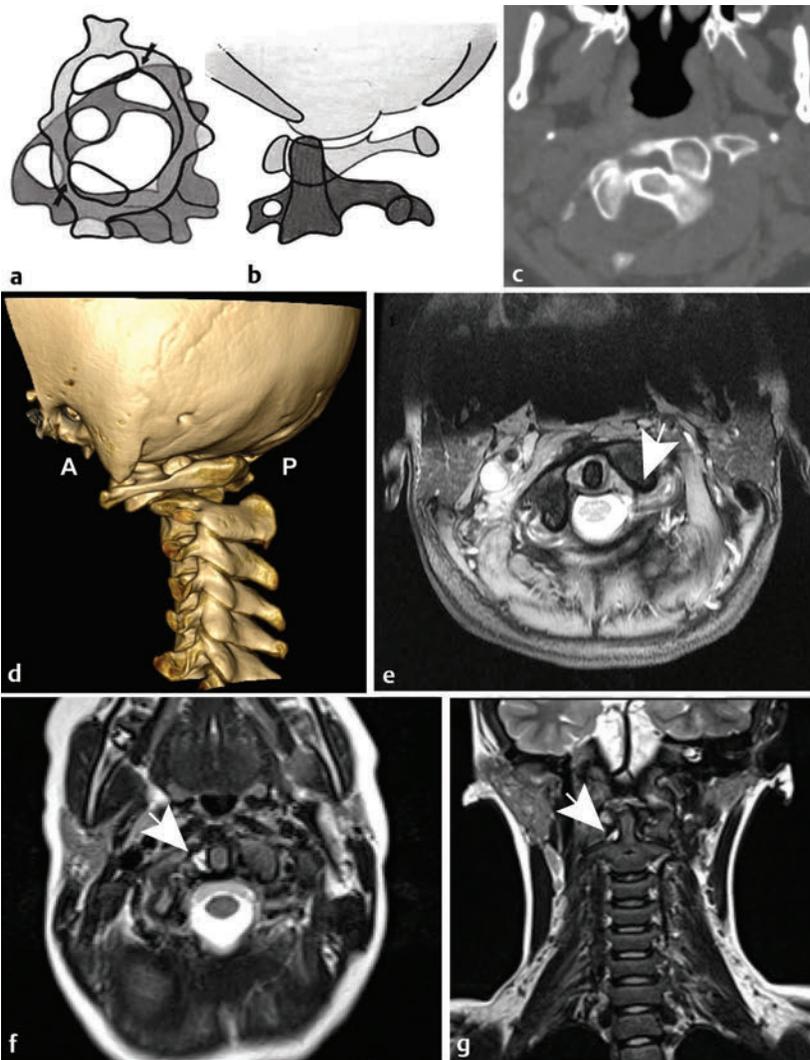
(a,b) Rotational changes at atlantoaxial articulation as a result of rotation exceeding 40 degrees with an interlock (arrows). (c) Axial computed tomographic scan showing C1–C2 interlock. (d) Three-dimensional reconstructed image indicates the abnormal bony configuration. A, anterior; P, posterior. (e) Axial T2-weighted image indicates rotation of C1 on axis with a torn cruciate ligament (arrow). (f) Axial T2-weighted image in another patient indicates increased signal intensity within the alar ligament, adjacent to the odontoid (arrow). (g) Coronal T2-weighted image indicates the presence of a torn alar ligament (arrow) in the same patient.
